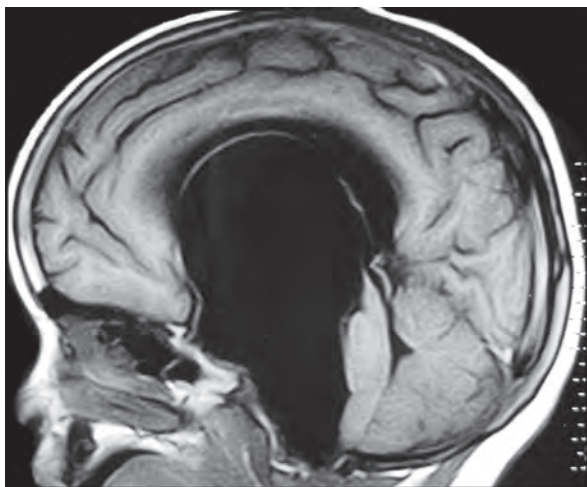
MRI of the brain sagittal T1W image showing arachnoid cyst with hydrocephalus
